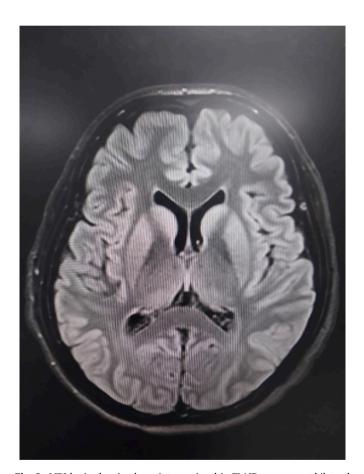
2. MRI brain showing hyperintense signal in DWI sequence with hypointense signal in ADC sequence at fronto-parieto-temporo-occipital lobe.
